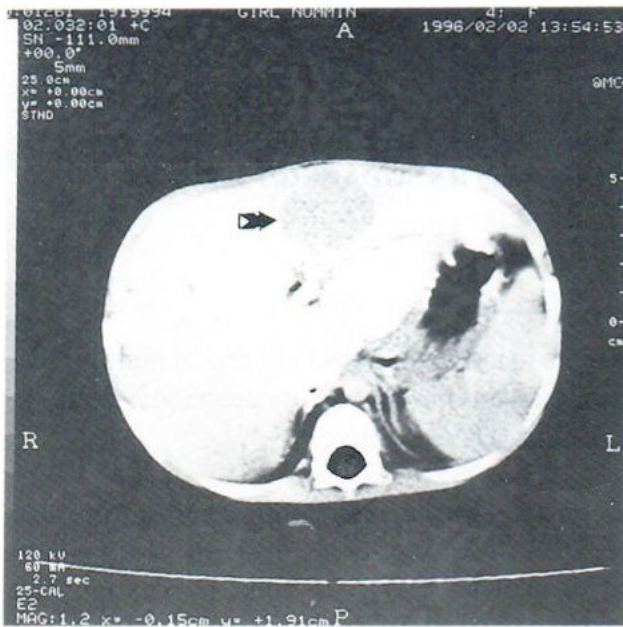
Contrast-enhanced CT scan shows a hypodense mass (arrow) in left liver lobe.
